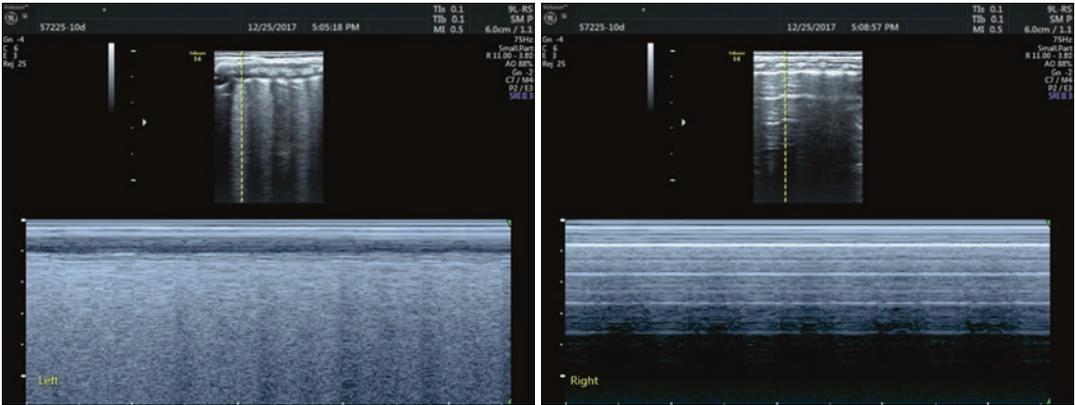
Severe pneumothorax. Severe pneumothorax in the right thorax. M-model ultrasound showed that beach sign in the left lung, while the stratosphere sign in the right lung
